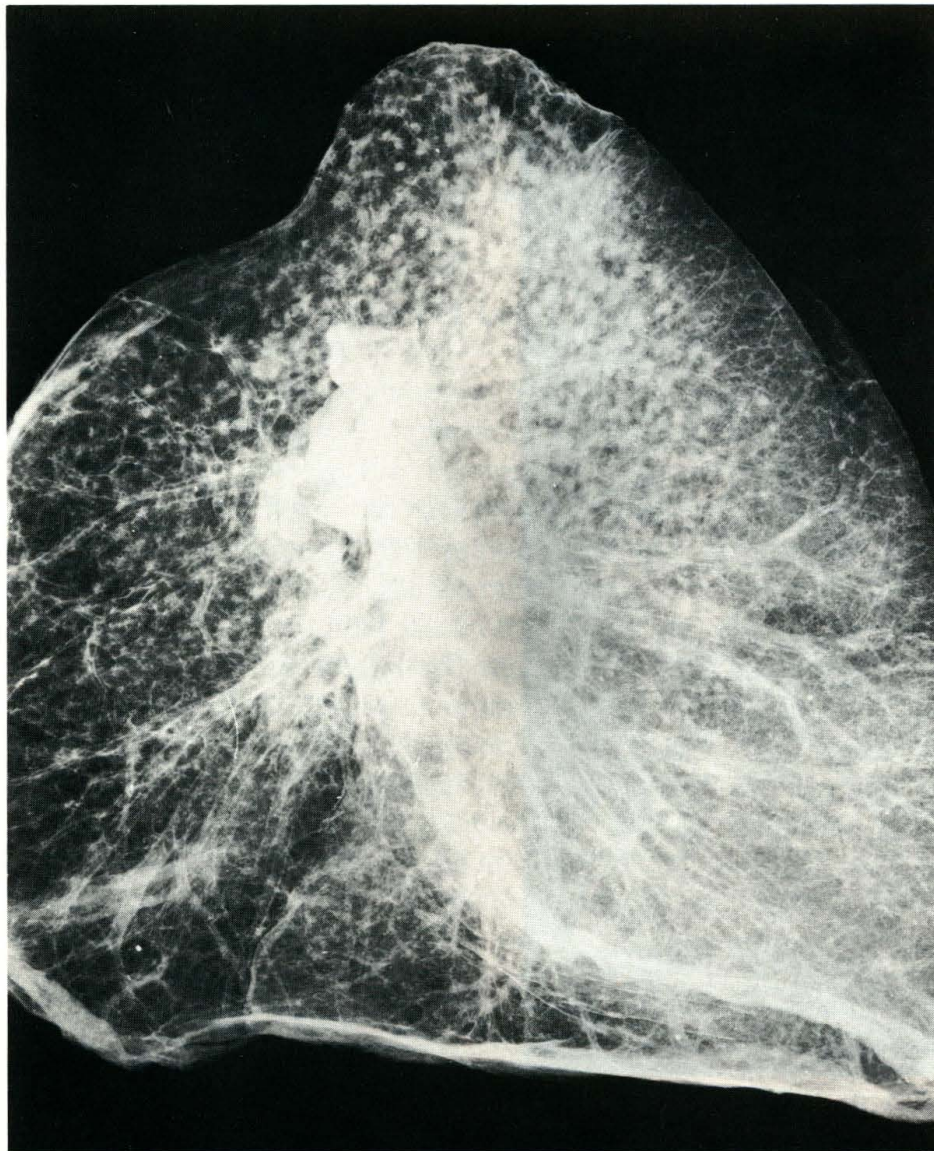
Left. Roentgenogram of 1-cm-thick slice of lyophilized (freeze-dried) lung. The round opacities correspond with micronodular lesions. Macular lesions are not resolved. Right. Whole lung section prepared from same slice showing micronodules and macules.
